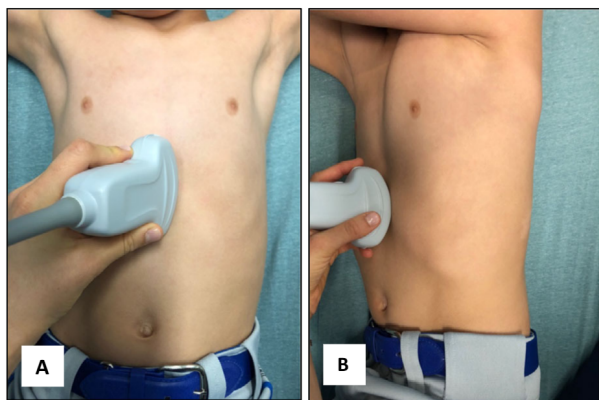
Patient positioning for gastric POCUS. Gastric POCUS is performed with a curvilinear probe in the epigastric location with a sagittal orientation in two positions: (A) right lateral decubitus and (B) supine with the upper body elevated, with the index marker pointing cephalad. POCUS = point-of-care ultrasound.
